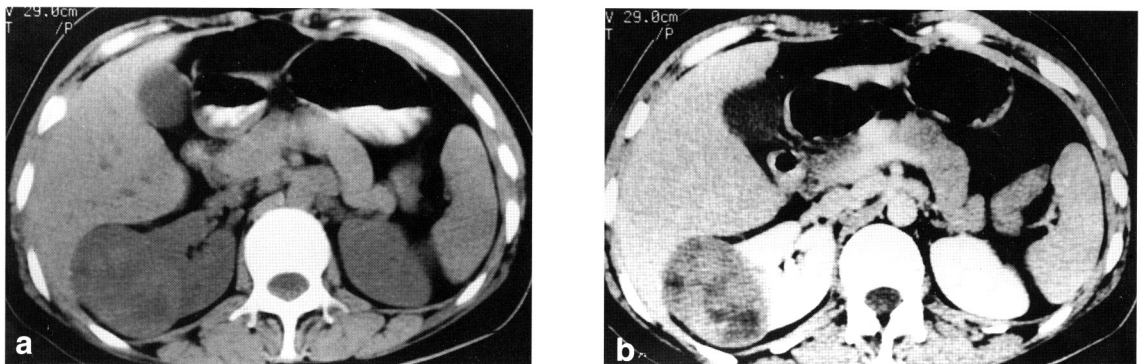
Abdominal CT scan shows an approximately 6 × 4 cm sized, well-defined, round, slightly hyperdense mass protruding from the interpolar area of the right kidney in the precontrast image (2a) and the postcontrast image shows a hypodense mass with multiple low density area consistent with hemorrhagic necrosis (2b).
